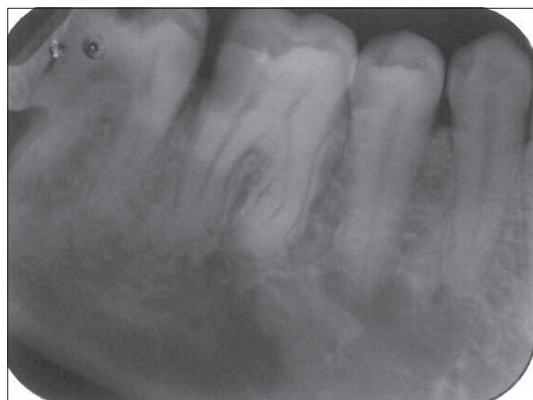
The second radiograph of mandibular premolar region from different angulation showed slight mesial shift in the periapical radiolucency with intact lamina dura.
